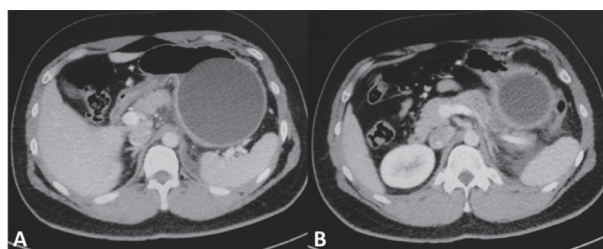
Computed Tomography Scan Results.
